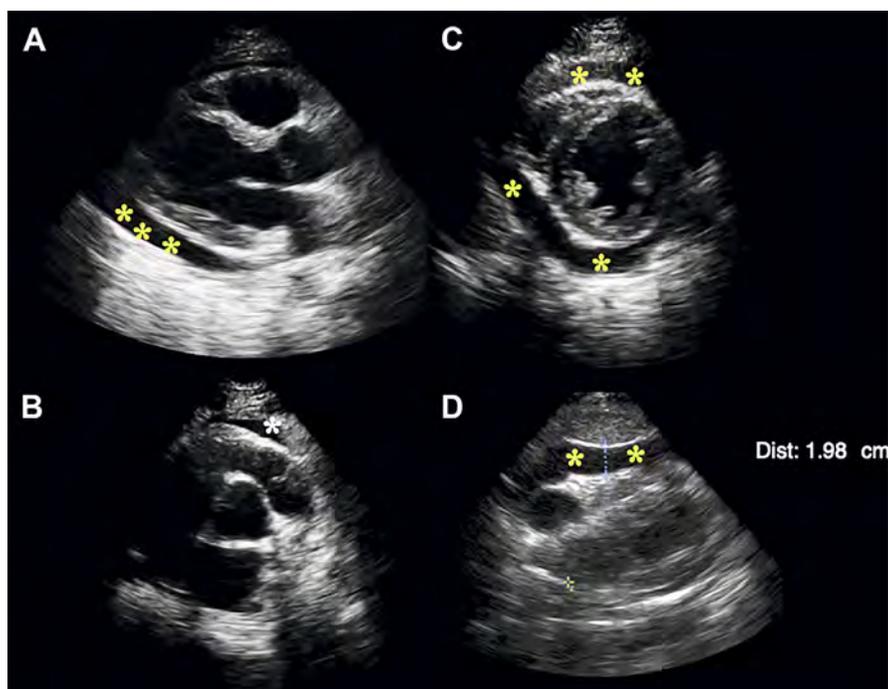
Visualization of pericardial effusion (*asterisk*) in different views. (A) Parasternal long view. (B) Parasternal short aortic valve. (C) Parasternal short midpapillary. (D) Subxiphoid view with a measured pericardial effusion of 1.98 cm (moderate) between the pericardium and RV free wall.
